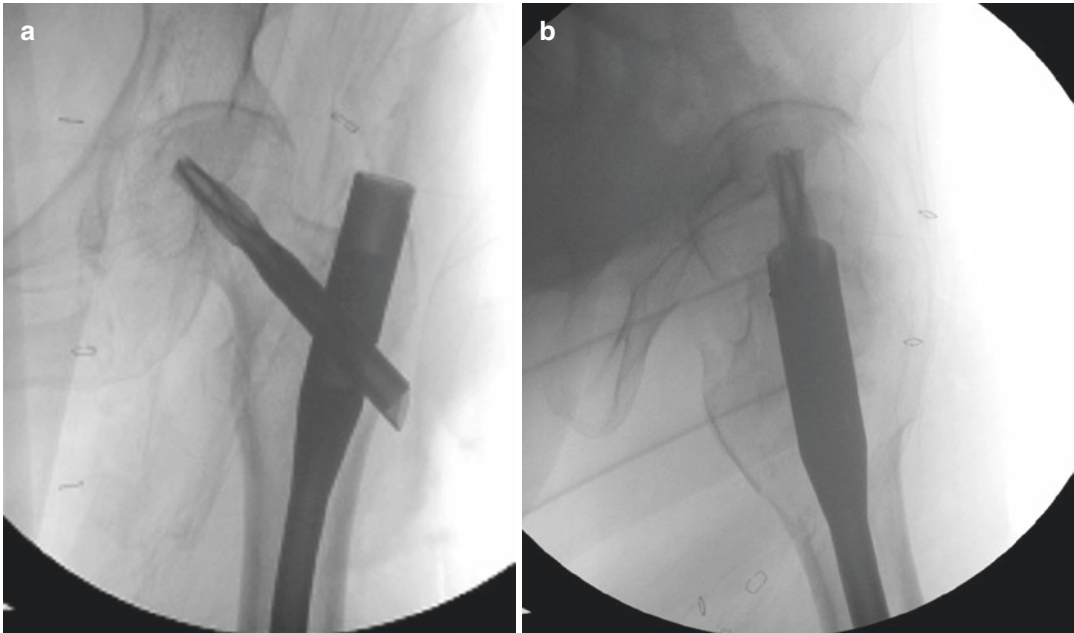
(a) AP radiograph demonstrating cutout of a SHS construct. (b) AP radiograph demonstrating cutout of a CMN construct
